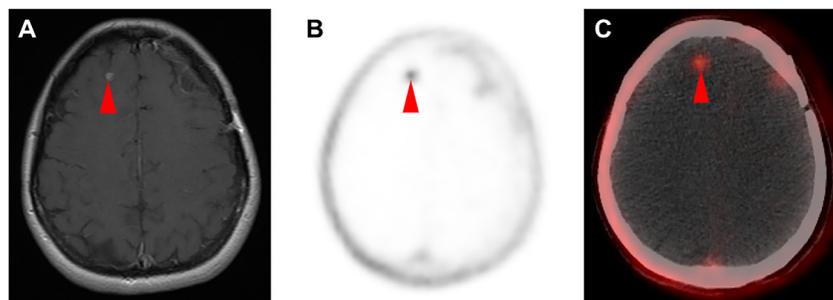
(A) Axial, T1, postcontrast magnetic resonance image, (B) axial ^{18}F -DCFPyL PET and, (C) axial ^{18}F -DCFPyL PET/CT images of the brain from a 40-year-old woman with history of metastatic clear cell renal cell carcinoma. The enhancing focus in the left frontal lobe (red arrowhead in (A)) is consistent with a site of metastatic disease, and this lesion has focal radiotracer uptake (red arrowheads in (B) and (C)). Postsurgical changes from prior left frontal craniotomy for resection of another metastatic lesion are also present.
